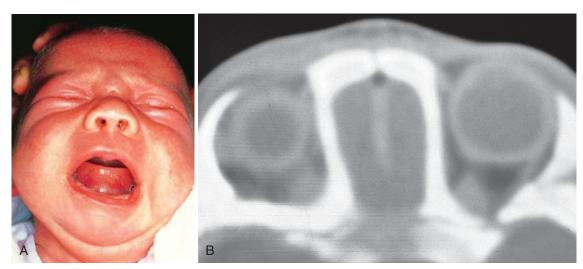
Nasal dermoid. A, A firm, round mass with a central dimple is seen over the bridge of this infant's nose. B, CT scan demonstrates a bony dehiscence of the nasal bridge with a nasal dermoid extending into the anterior cranial vault in the area of the foramen cecum.
